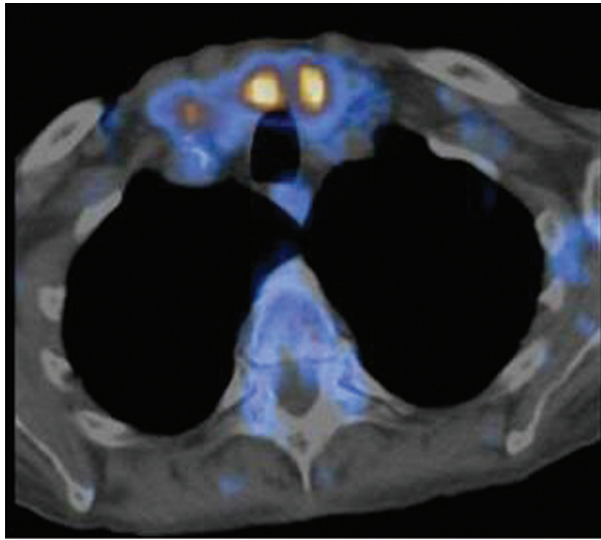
Fused [^{18}F]FDG PET-CT images in a patient with renal cancer showing two areas of uptake of tracer in the right and left lobes of the thyroid; subsequent investigation showed these to be nodules in a multi-nodular goitre.
